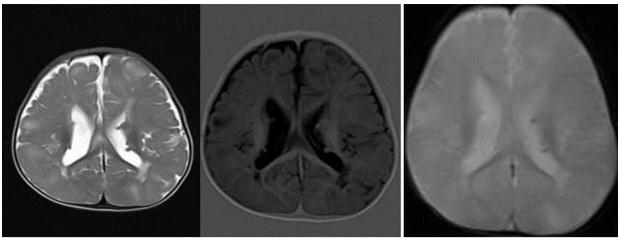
MRI Brain (plain axial) – T2WI (A), T1WI (B) and GRE (C)
